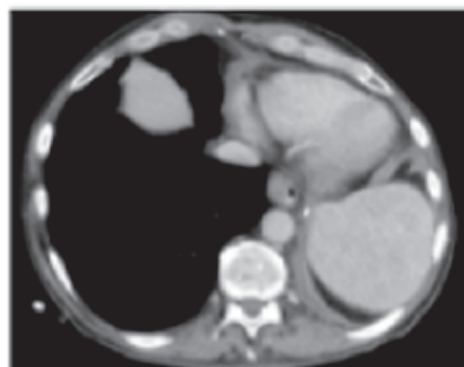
(A) CT chest at diagnosis demonstrating right lower lobe lesion with “reverse halo sign” and contiguous splenic involvement. (B) CT Chest following clinical deterioration post lobectomy demonstrating bilateral pleural effusions and peri-bronchial consolidation with a second splenic lesion. (C) CT Chest 11 weeks post isavuconazole therapy demonstrating resolution of the splenic lesions. Abbreviations: CT=computed tomography.
